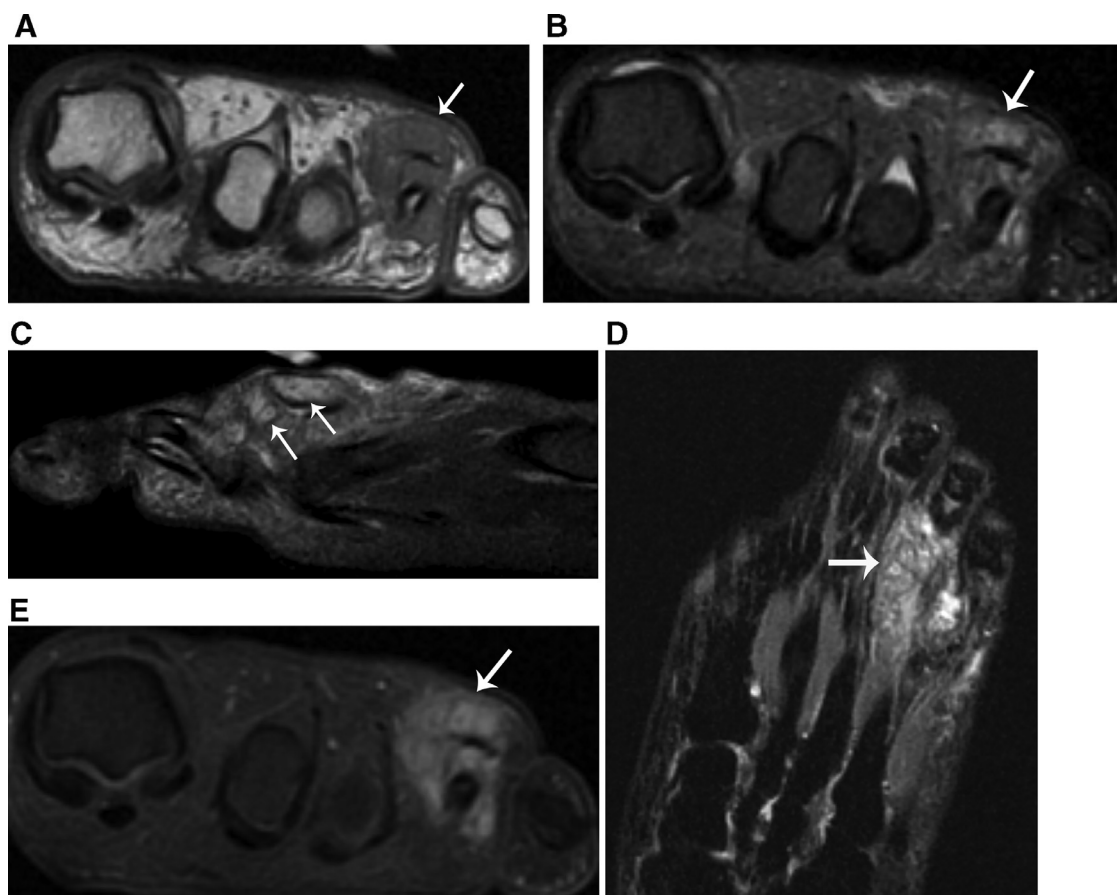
(a–e) MR imaging performed on prior visit (2 years before current encounter). Axial T1-weighted image (3a) shows a soft tissue lesion dorsal to the fourth metatarsal head insinuating into the third and fourth web-spaces. Axial (3b) and sagittal (3c) T2-weighted fat-saturated images and coronal STIR image (3d) show a heterogeneously bright signal intensity lesion with multiple rounded foci encircling small low signal intensity dots. Axial T1-weighted fat-saturated image obtained after intravenous administration of gadolinium-based contrast (3e) shows enhancement of the lesion. The central dots lack significant enhancement.
